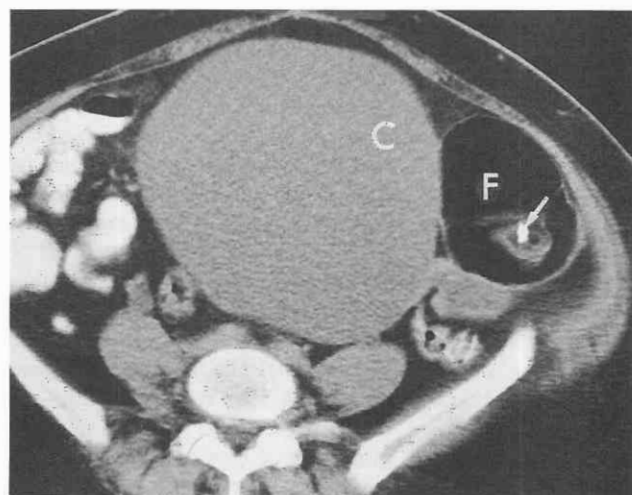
Bilateral benign teratomas. *Left*, CT scan shows a typical benign teratoma containing fat (F) and dental elements (arrow). *Right*, A pure cystic teratoma (C) is seen.
